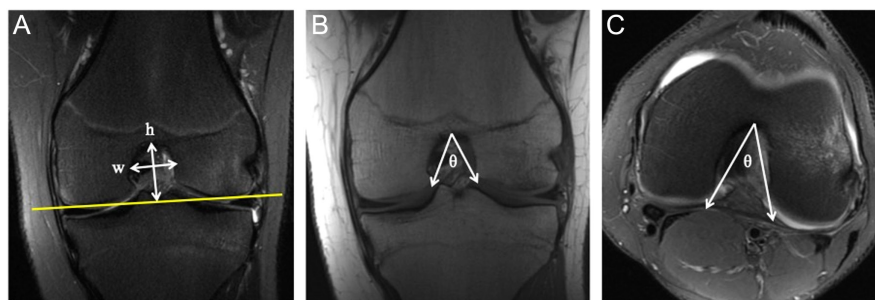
Femoral intercondylar notch measurements using MRI. (A) Coronal T2-weighted MRI image shows the determination of the intercondylar notch height (h) and intercondylar notch width (w). A reference axis (yellow line) using the most inferior aspect of the bilateral femoral condyles is used to draw a line to the most superior point of the notch (h). A line marking the internal borders of the notch (w) is drawn to calculate the notch width. (B) Coronal T1-weighted MRI image shows the determination of the intercondylar notch angle (θ). Two lines extending out to the distal medial and lateral notch borders are drawn to calculate the angle. (C) Axial T2-weighted MRI image shows the determination of the intercondylar notch angle (θ). Two lines extending out to the posterior aspect of the medial and lateral notch borders are drawn to calculate the angle. MRI, magnetic resonance imaging
